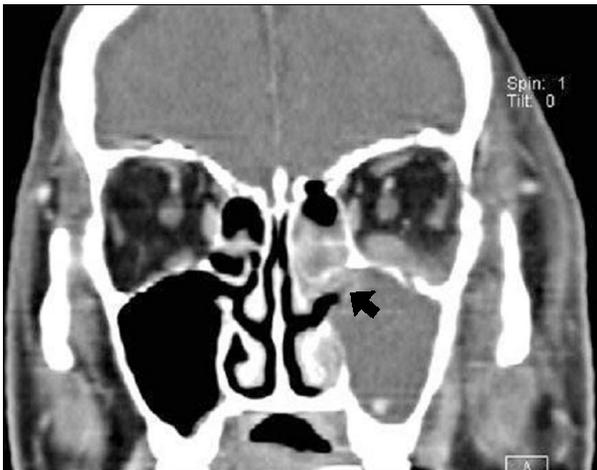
Computed tomography scan showed left maxillary and frontoethmoid sinus inflammation with extension into inferior part of left orbit.
